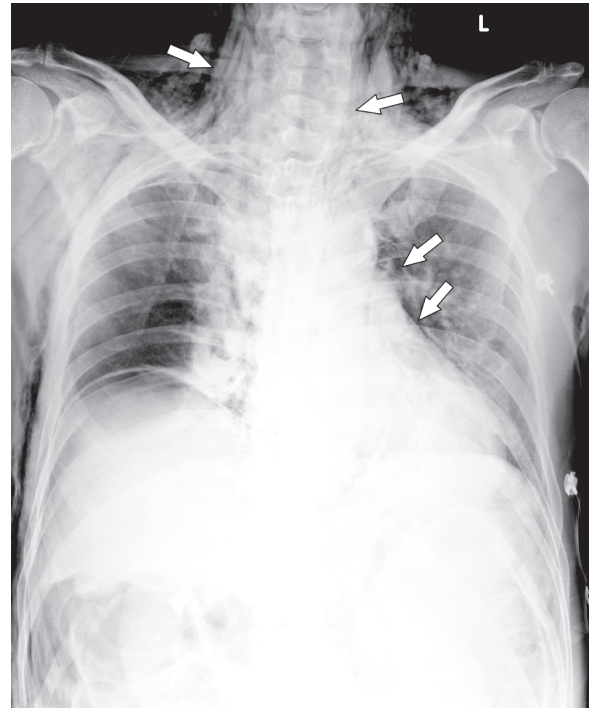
Chest radiograph showing an air outlining of the mediastinum (white arrows) with upward extension along the trachea into the neck.
